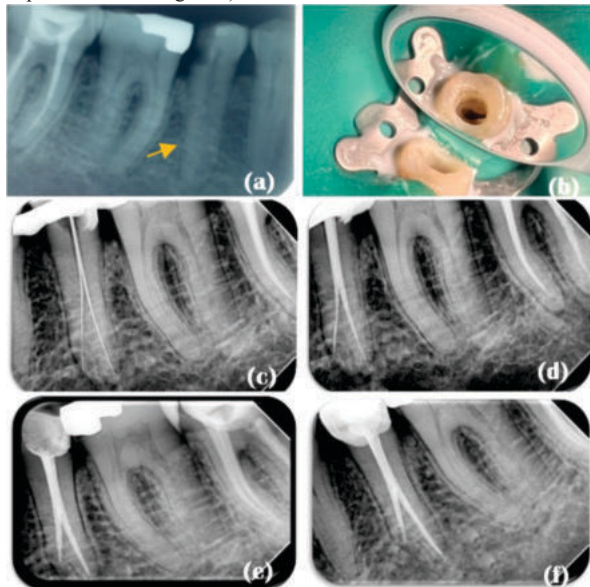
(a) Pre-operative radiograph (b) Access opening under rubber dam (c) Working Length Determination (d) Master Cone Fit (e) Obturation (f) 3 month follow up
